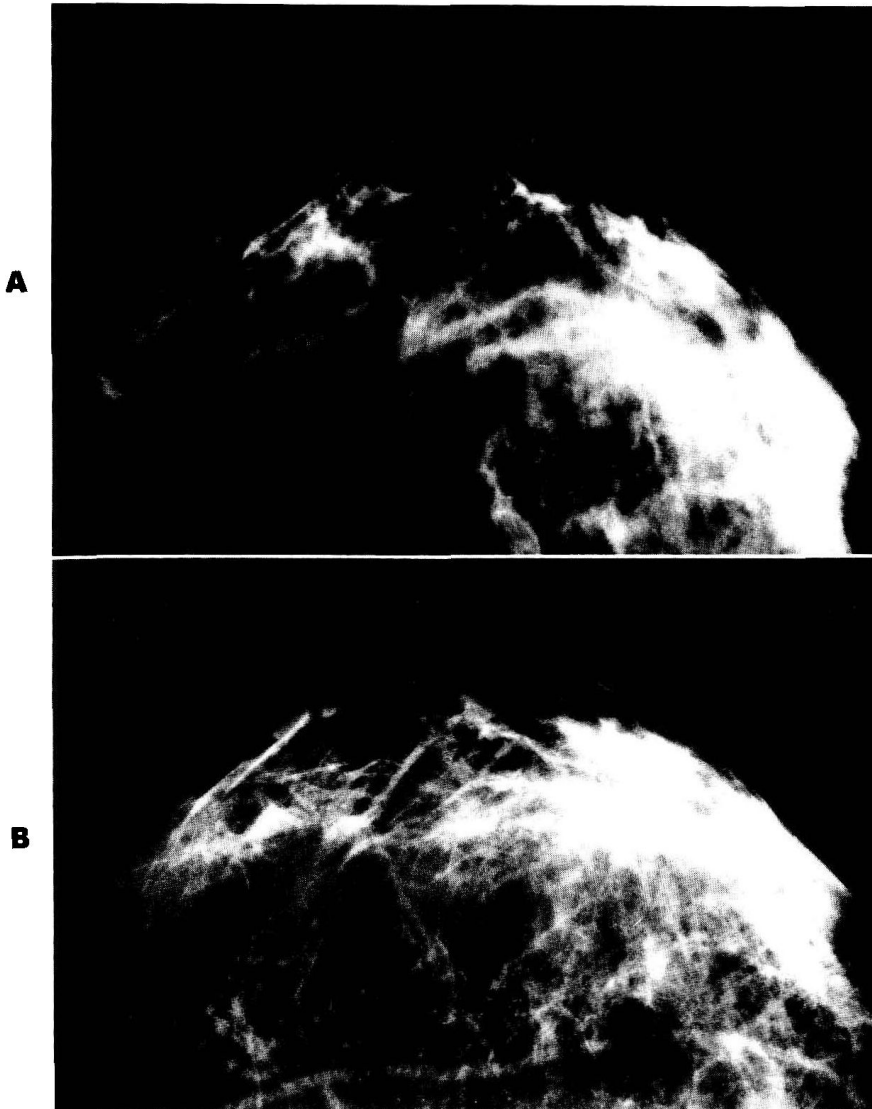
Monthly cyclic changes. Numerous vague densities in the breast become more prominent in the premenstrual phase (A) as compared with midcycle (B). This variability is seldom noted radiographically.
